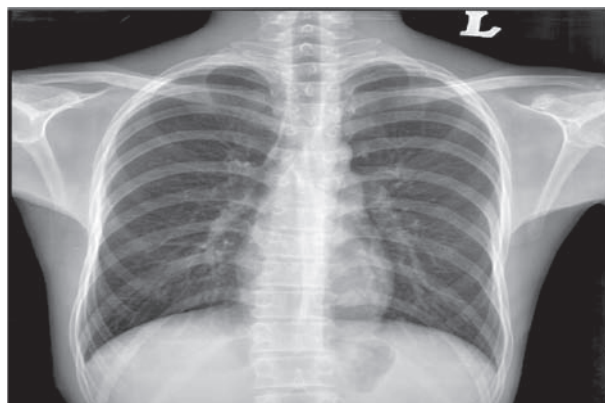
Follow-up chest x-ray showing resolution of patchy infiltrates in both lungs.
